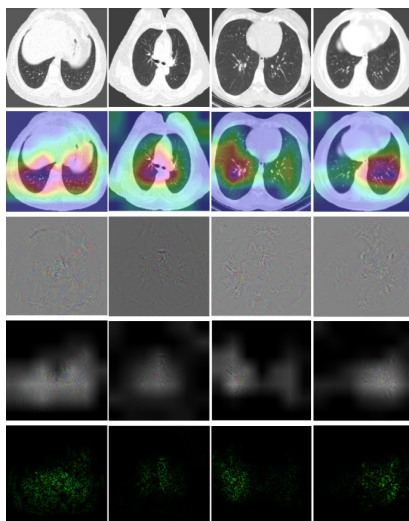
Sample chest CT images of normal cases and their associated characteristics identified by the proposed model.
